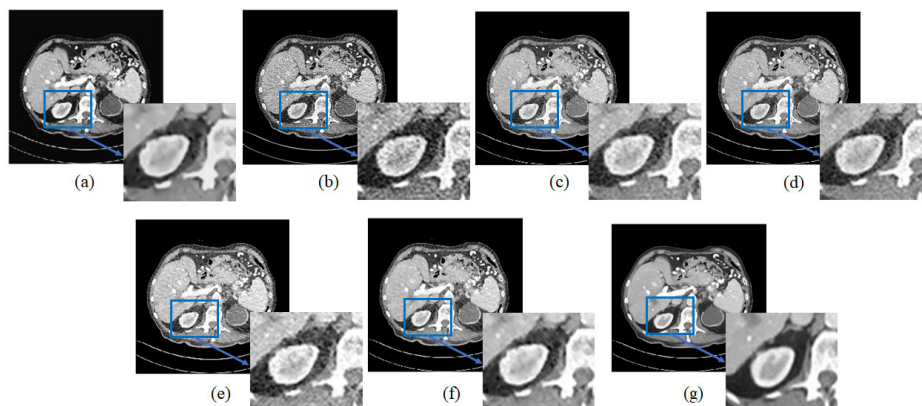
Denoising by different algorithms on the benchmark low-dose CT (Mayo clinic) scans of abdomen on 32-year male with id L033 [47]: (a) Normal dose image, (b) Corresponding LDCT image, (c) PURE [42], (d) MAP-NN [39], (e) CPCE [38], (f) AdaIN CycleGAN [41], and (g) Proposed.
